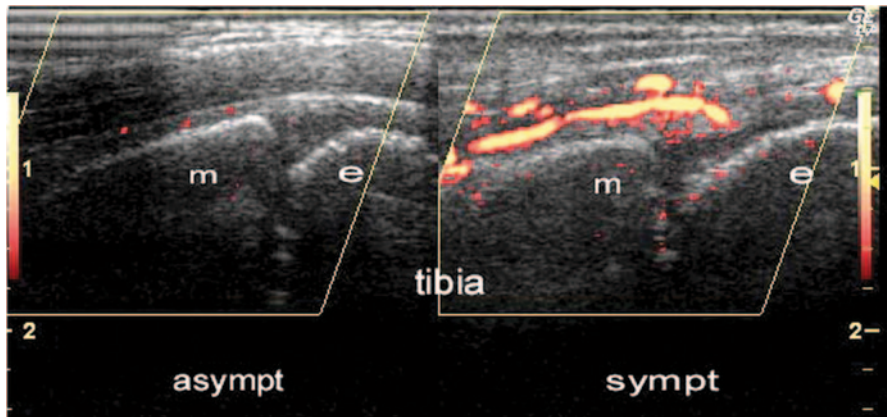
Acute osteomyelitis at the distal end of tibia. Longitudinal power Doppler US of the symptomatic and asymptomatic ankles. The power Doppler signal was asymmetrically increased over the metaphysis and epiphysis of the distal left tibia (*symptomatic*). In children younger than 18 months of age, transphyseal vessels allow vertical spread of infection from the metaphysis, through the physis into the epiphysis and joint space. *m* metaphysis, *e* epiphysis, *asympt* asymptomatic, *sympt* symptomatic
